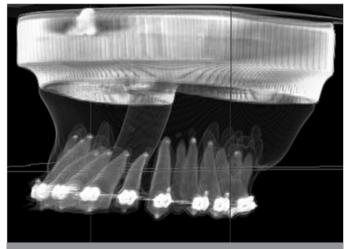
The CBCT image with reference points that were bonded to the apex and to the tubercle tips of the premolars
